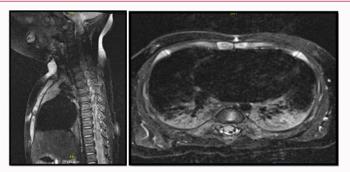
Postoperative MRI: Findings declining with small residual T2-hyperintense (approx. 4 mm × 3 mm × 9 mm) focus and constantly low bone edema in the middle third of the sternum.
